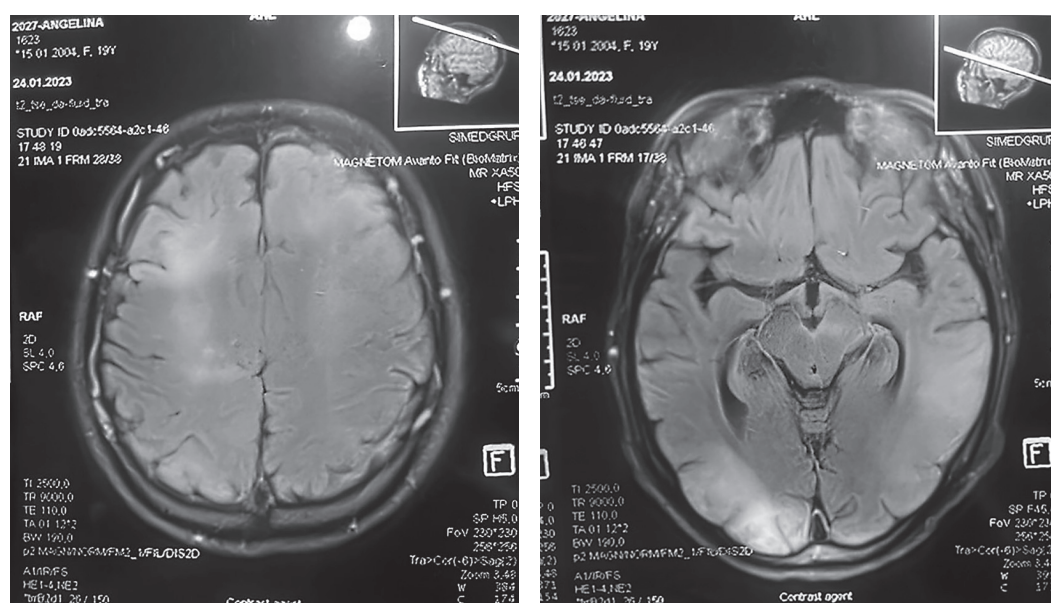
Brain magnetic resonance imaging of a 19-year-old perinatal HIV-infected female with subacute sclerosing panencephalitis.
